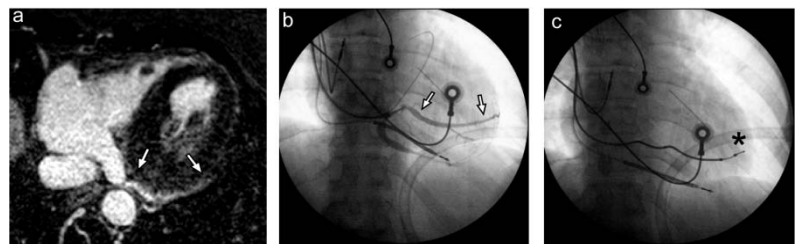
Coronary vein images acquired by MRI (a) and by Retrograde Venography (b). Arrows point at the PVLV, the vein used for LV lead implantation. The final lead placement is shown by a (*) in a non-contrast image (c).
